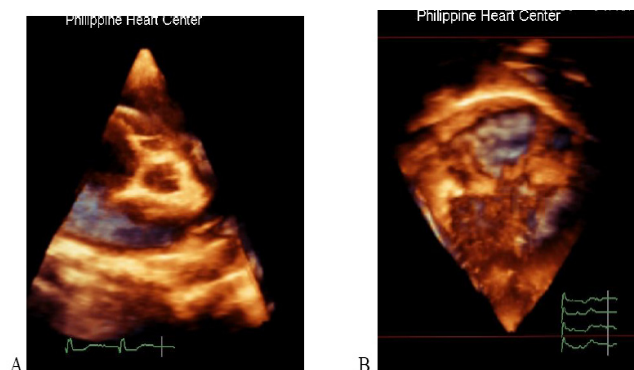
Real-time 3-dimensional echocardiographic display of the atrial septal defect viewed en face from the parasternal short axis (A) and apical four chamber view from the right atrial side.
